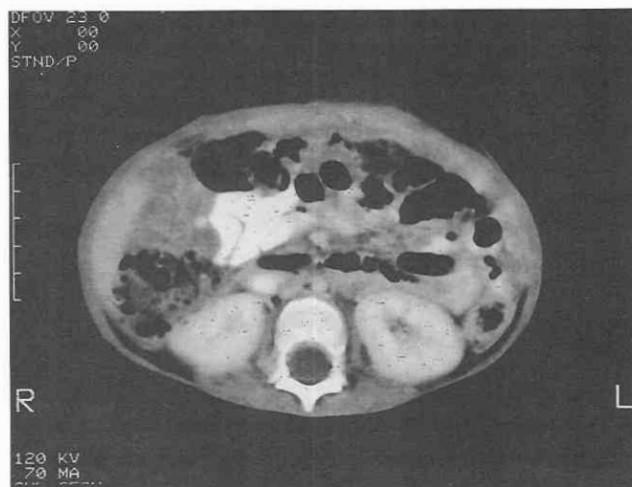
Peritoneal implant. CT scan through the upper abdomen demonstrates a peritoneal implant in Morison's pouch.
